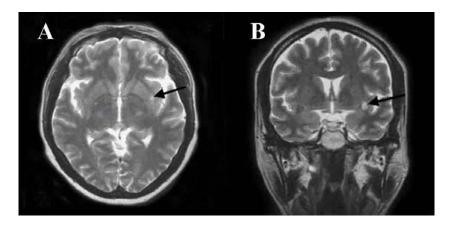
Brain magnetic resonance imaging (MRI) showing a high signal intensity lesion in the corpus striatum on T_2W (A) (horizontal view) and FLAIR (B) (coronal view).
